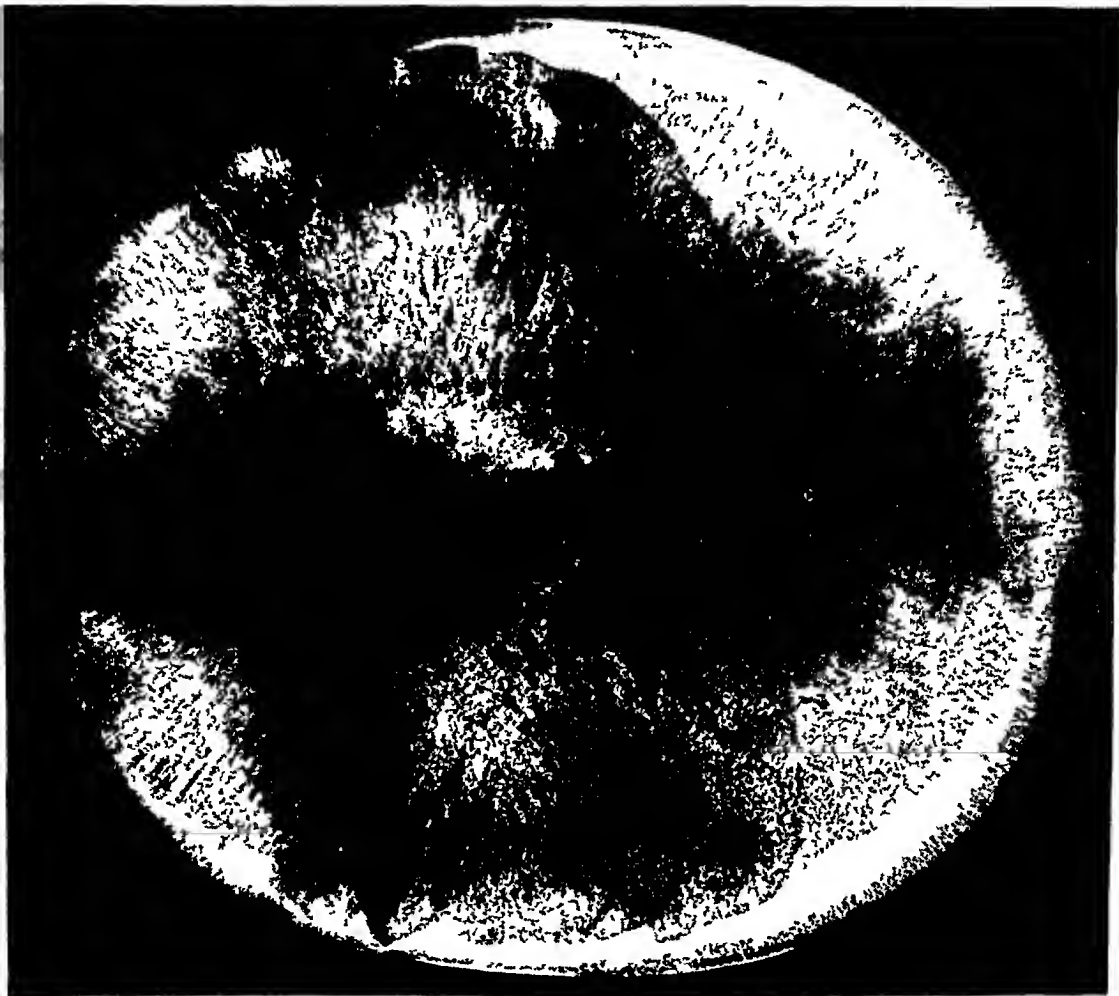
Roentgen-ray of skull-cap of M A, showing radiating lines of new bone formation
